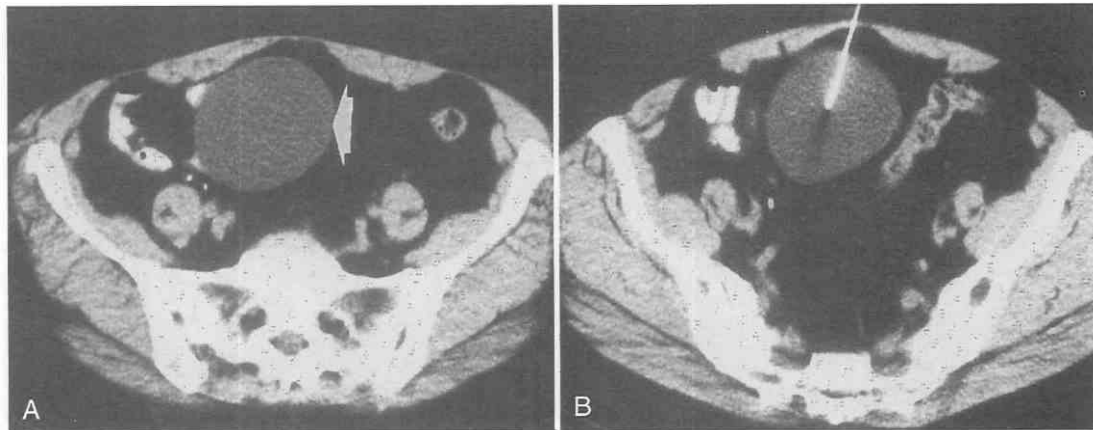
Mesenteric cyst. A, CT scan shows a mass (arrow) that proved to be a mesenteric cyst. B, CT-guided procedure proved the true nature of the mass. The trajectory chosen avoids any loops of bowel, thereby preventing the possibility of contamination.
